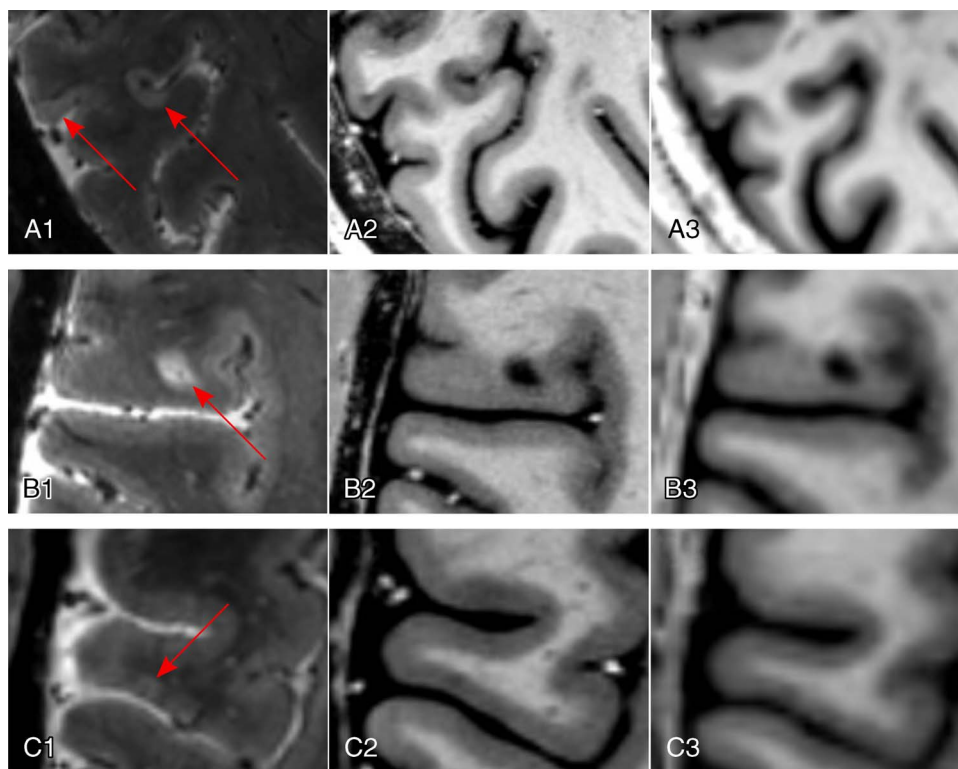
Cortical MS lesions. Ultra-high-field imaging at 7 T allows for detection of all types of cortical MS lesions (red arrows; A1–A3, subpial lesions; B1–B3, leukocortical lesion; C1–C3, intracortical lesion), exemplified using a T2*-weighted gradient echo sequence (T2*w GRE; spatial resolution, 0.5 mm isotropic) for the detection of a subpial lesion (A1), a leukocortical lesion (B1), and an intracortical lesion (C1). T1-weighted sequences, such as the magnetization prepared 2 rapid acquisition gradient echo (MP2RAGE), are also sensitive to cortical MS lesions at 7 T (A2, B2, C2; spatial resolution, 0.5 mm isotropic; average of 4 acquisitions) compared with 3 T (A3, B3, C3; spatial resolution, 1 mm isotropic; single acquisition).
